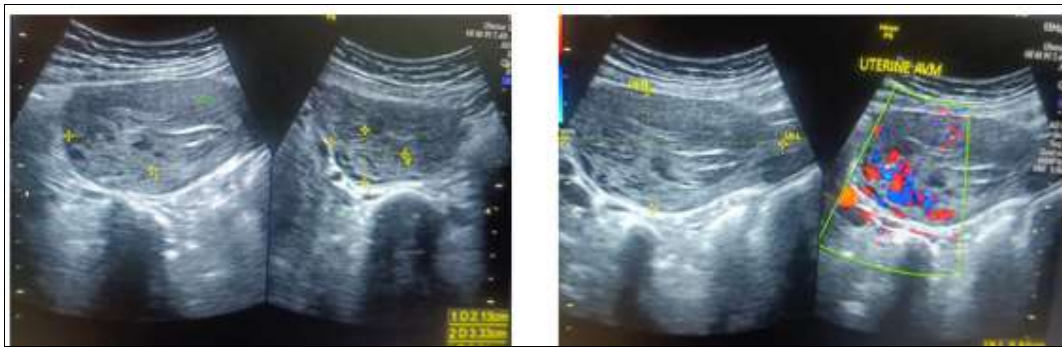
Ultrasound Images depicting uterine AVM
